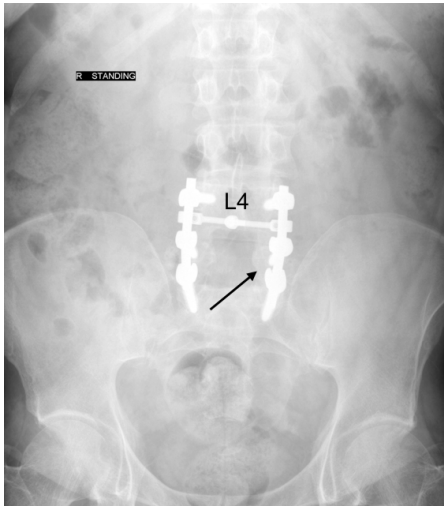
2-week post-operative, standing, anteroposterior lumbar spine x-ray showing intact pedicle screws and rods at L4-S1.
